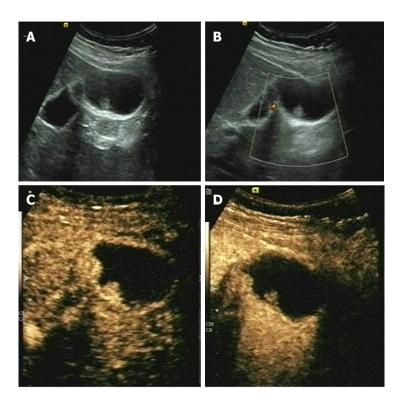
Gallbladder polyps in a 38-year-old male patient. A: B-mode sonography showed a homogeneously isoechoic lesion in the gallbladder, with an intact gallbladder wall; B: Color Doppler ultrasound showed no color Doppler signal in the lesion. According to A and B, a diagnosis of probably benign was made. C: CEUS showed a homogeneous and a little hyperenhanced lesion in the gallbladder on arterial phase; D: CEUS showed the enhancement of the lesion is similar to the surrounding gallbladder wall on venous phase. According to C and D, a diagnosis of benign lesion was made. CEUS: Contrast-enhanced ultrasound.
